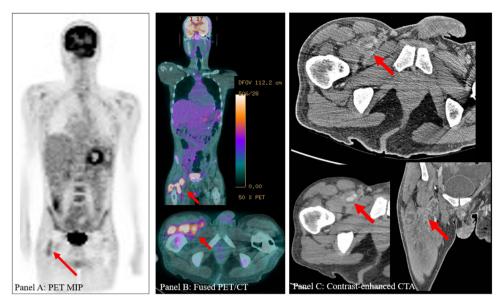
¹⁸F-FDG PET/CT images of a right thigh mycotic aneurysm with perivascular abscesses. PET MIP (A) image demonstrates a hypermetabolic linear focus in the proximal right thigh (arrow). An additional peripherally hypermetabolic focus is seen in the abdomen in the left upper abdomen (see Fig. 2). Axial/coronal PET/CT fusion (B) images demonstrate intensely hypermetabolic foci (arrows) associated with vasculature and musculature of the anterior right thigh. Axial/coronal contrast-enhanced CTA (C) images demonstrate rim-enhancing fluid collections in the anterior right thigh with irregular focal outpouchings originating from the right profunda femoral artery (arrows), consistent with mycotic aneurysm and abscesses.
